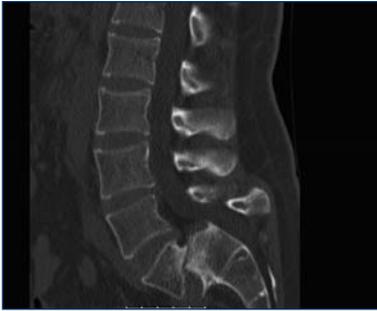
Pre-operative sagittal CT scan showing Grade III spondylolisthesis.
